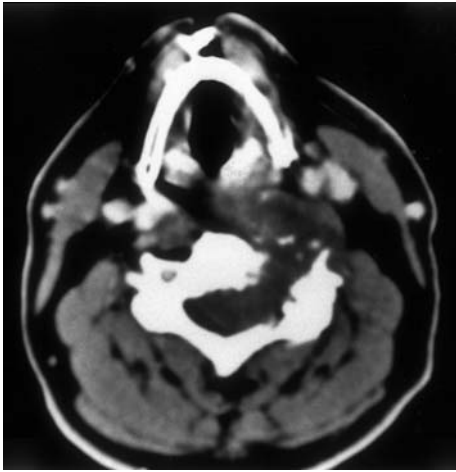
Chordoma of C3 vertebra. The CT shows a soft tissue mass causing enlargement of the left intervertebral foramen. Note the internal foci of calcification and the extension of the mass anteriorly
